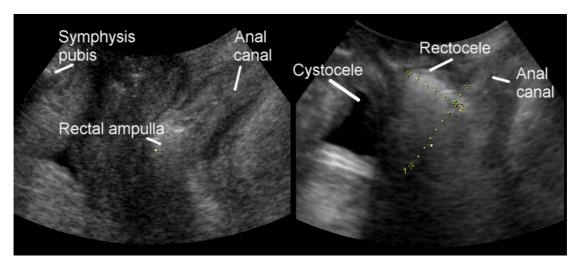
Quantification of a true rectocele on translabial ultrasound. Measurements indicate width (3.3 cm) and depth (1.9 cm) of a rectovaginal septal defect which is apparent as a discontinuity in the anorectal muscularis. Image at left is at rest, on right at maximal Valsalva.
